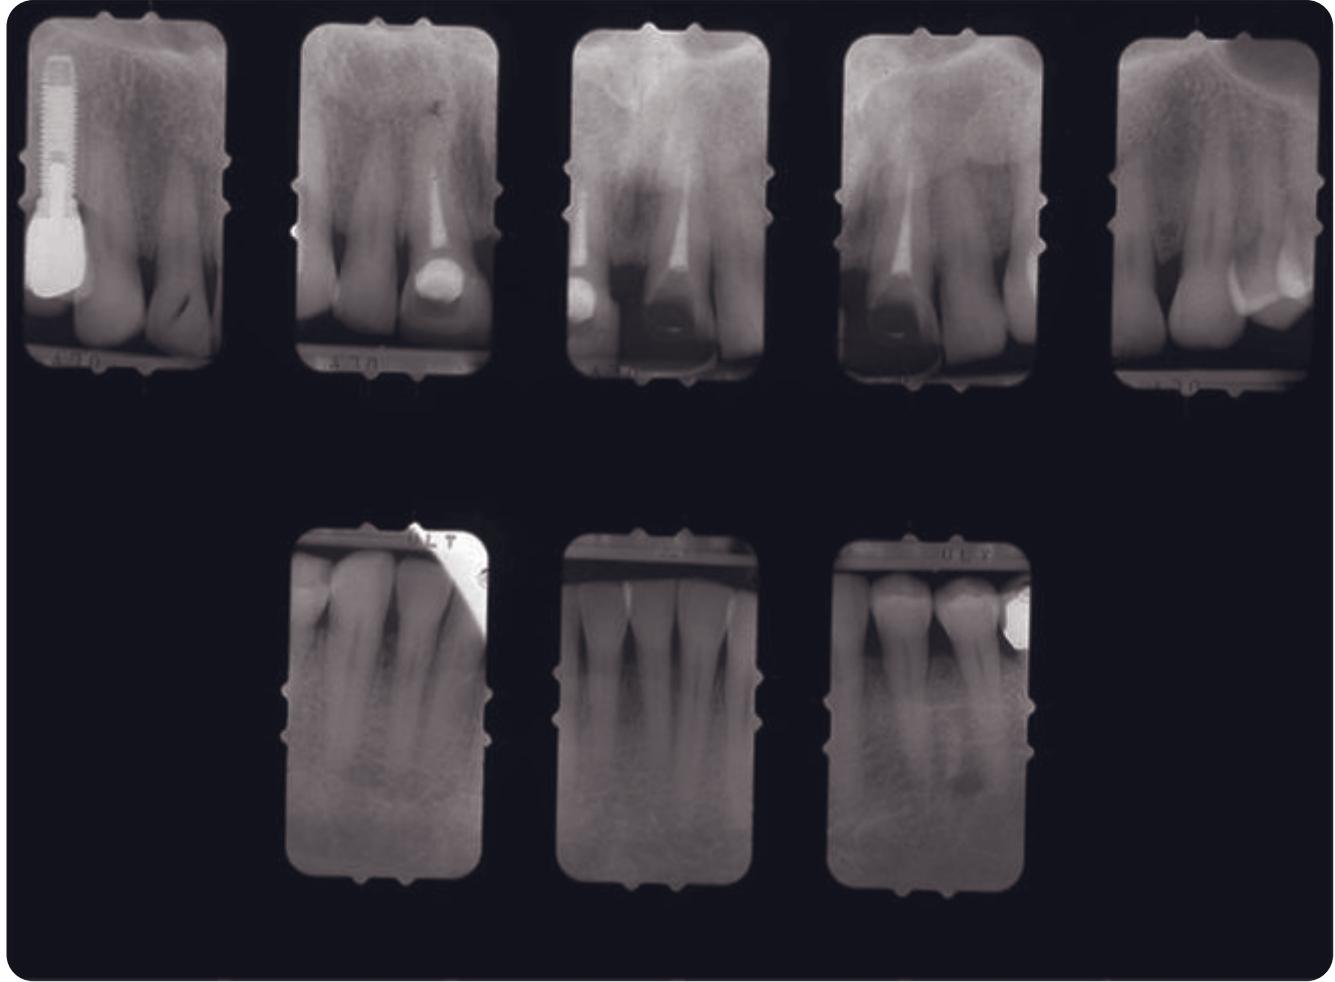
Pretreatment anterior radiographs. Note short endodontic fills on the maxillary central incisors.
